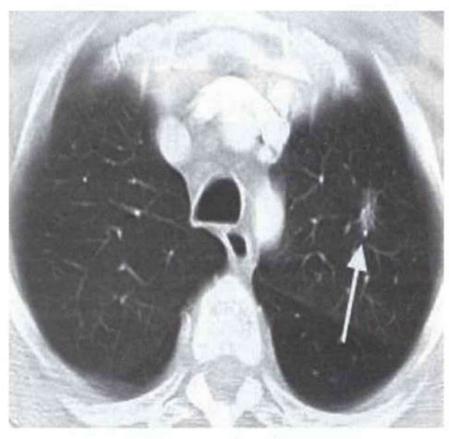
Bronchioloalveolar cell carcinoma. CT scan shows a mixed solid and ground-glass nodule in the left upper lobe (arrow).
